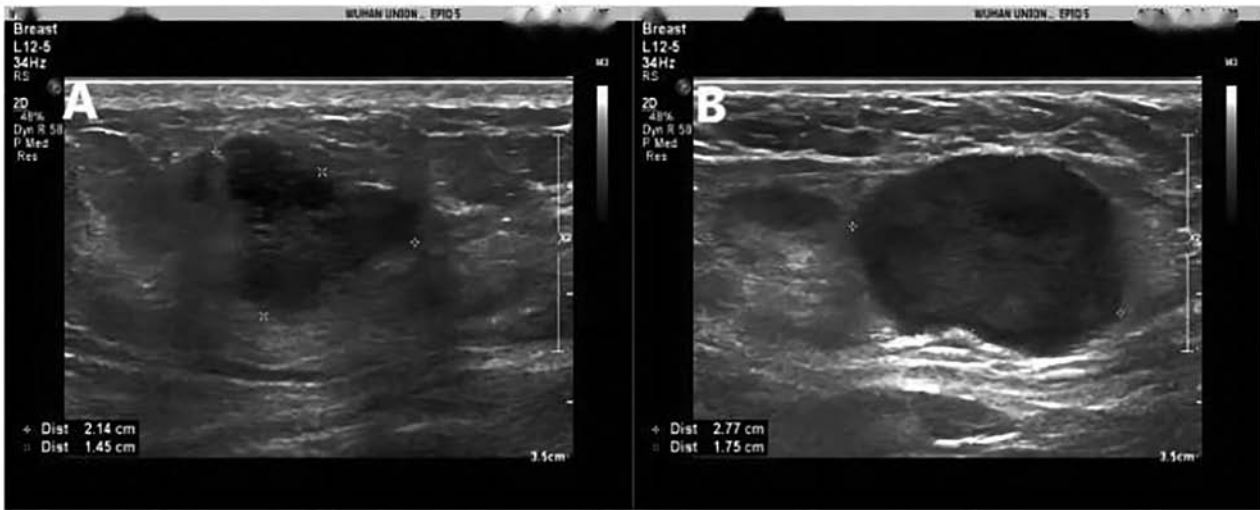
Ultrasound images of the left breast and axillary lymph nodes. (A) A 21.4x14.5-mm, irregularly-shaped and hypoechoic mass was visible in the 2 o'clock orientation of the left breast. (B) Several abnormal lymph nodes were present in the left axillary.
